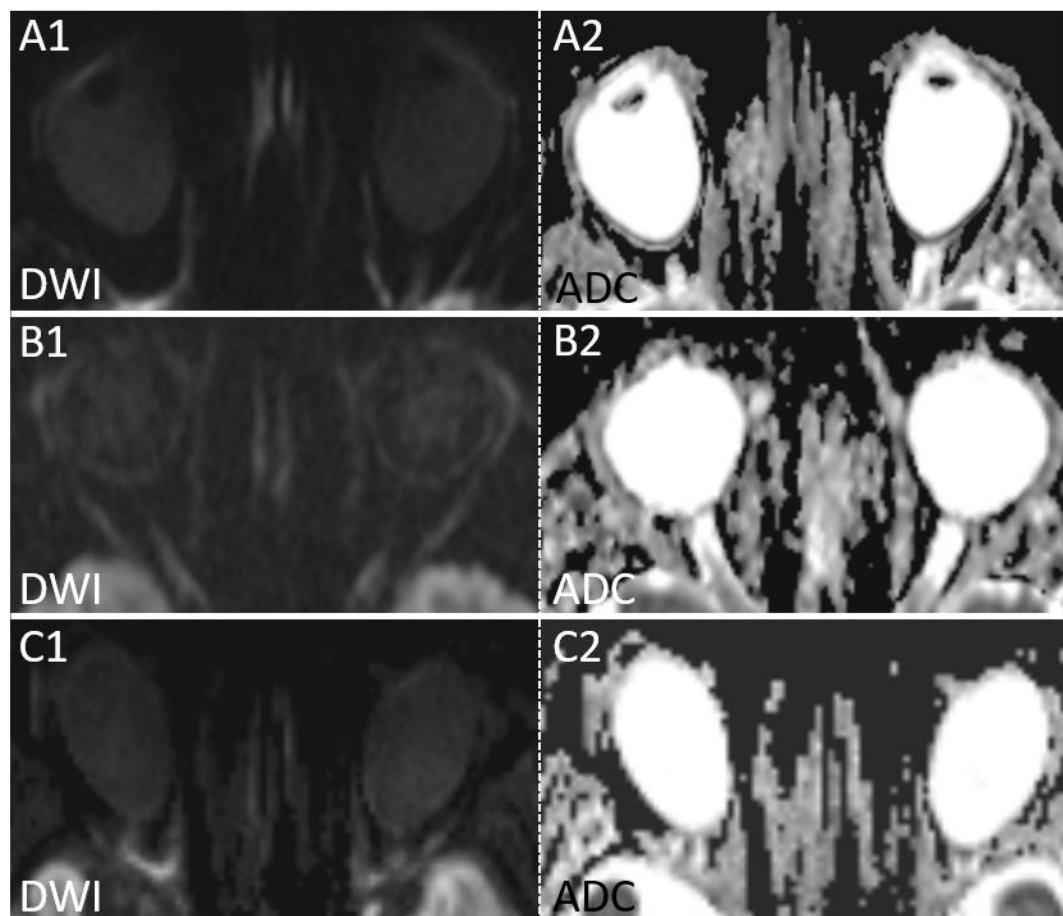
Examples of negative DWIs in acute CRAO (traced DWI $b=1000 \text{ s/mm}^2$ and corresponding ADC). Case 1 (A1/A2): 3T DWI-EPI MRI, left-sided CRAO. Case 2 (B1, B2): 1.5T DWI-EPI MRI, right-sided CRAO. Case 3 (C1, C2): 3T DTI-EPI MRI, right-sided CRAO.
